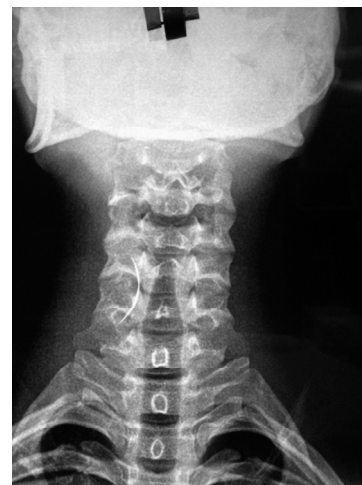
X-ray soft tissue neck (antero-posterior view) showing a radiopaque foreign body in prevertebral soft tissue shadow at the level of 4th, 5th and 6th cervical vertebrae
